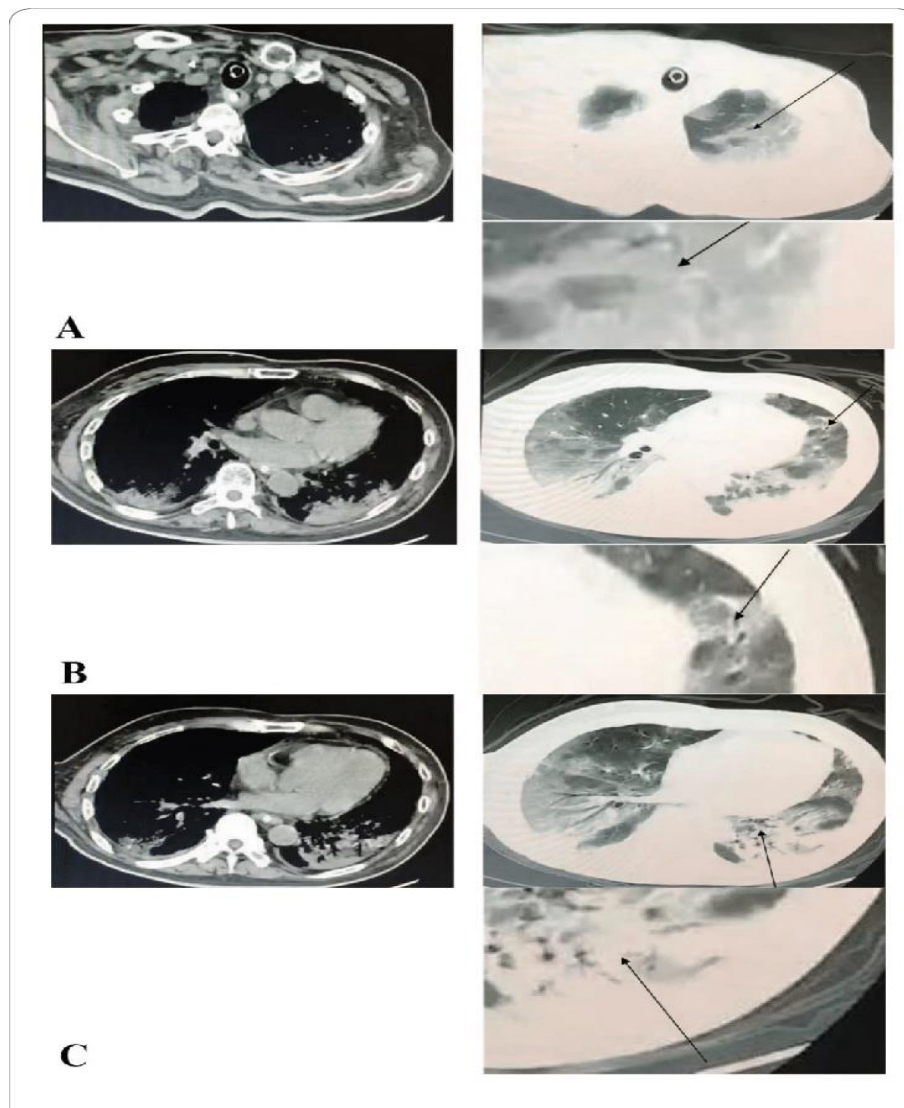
CT Imaging in a COVID-19.
